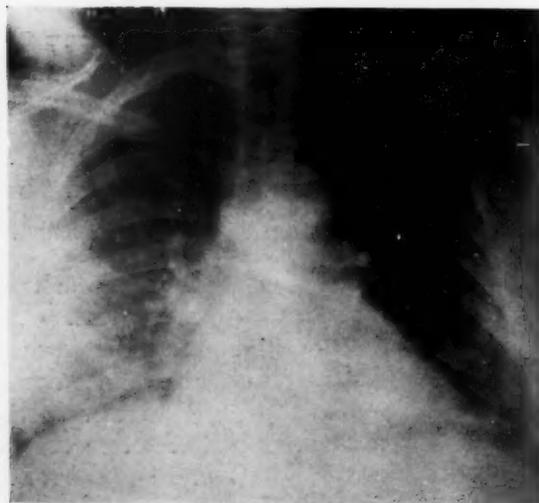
Case IV. Aged fifty-six. Changes reported as fibrosis. Twenty-one monthly roentgen treatments of unknown intensity plus 3,870 mg-hr. of radium had been employed. It was only after a most careful search that cancer cells were found in a lymph space.
